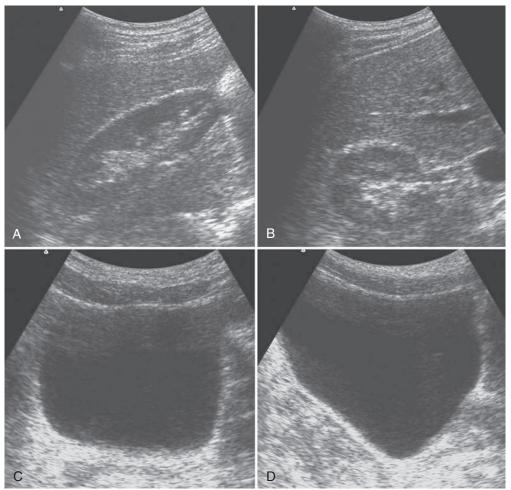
Imaging planes for renal and bladder sonography. (A) Longitudinal image of right kidney. Upper pole should be on left side of the image. (B) Transverse image of right kidney through the renal hilum. (C) Transverse image of urinary bladder. Anteroposterior and mediolateral dimensions are obtained in this plane. (D) Sagittal image of the urinary bladder. Superior portion of the bladder is to the left. Superior dimension is obtained in this plane.
